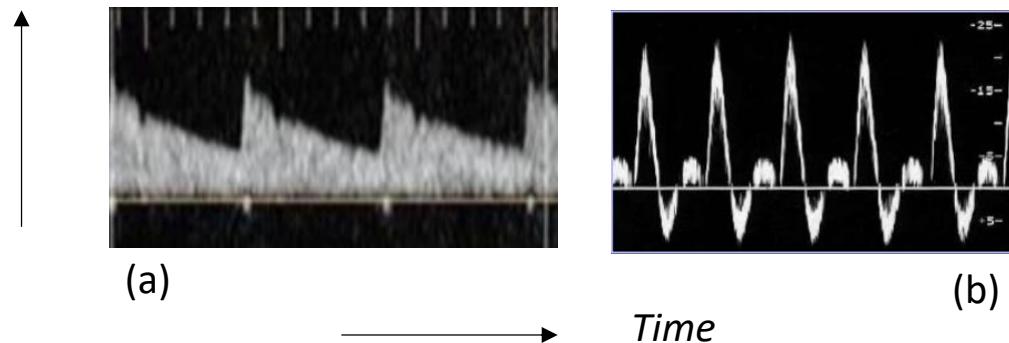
Two examples of spectral Doppler.
